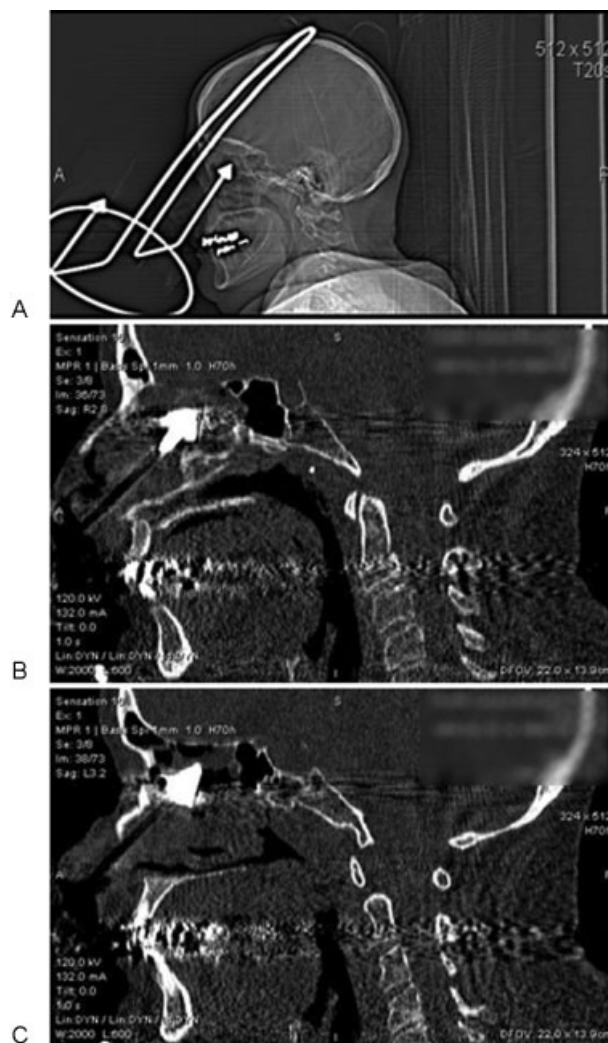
Computed tomography of the head. The scout image (A) and sagittal reconstructions (B and C) show one of the rods of the toilet paper holder extending through the nose and up to the skull base. The conical tip is in direct contact with the cribriform lamina.
